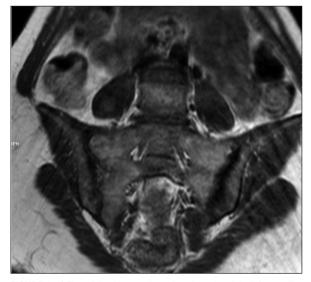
a) T1-weighted image shows hypointensity of the left sacroiliac joint
